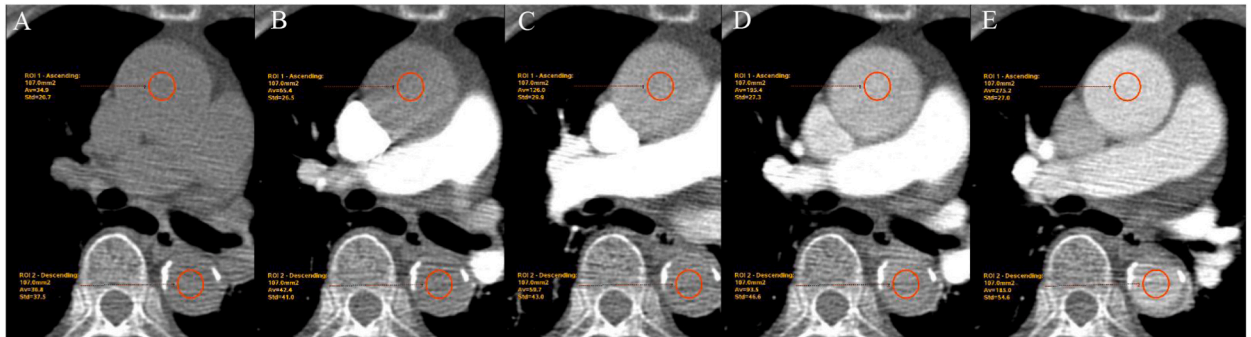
Retrospective analysis of monitoring images in a 74-year-old women underwent single energy scan. (A) The monitoring of tracheal bifurcation levels at the 8 s after the contrast injection. The ascending aortic region of interest (ROI) had a background computed tomography (CT) value of 34.8 hounsfield unit (HU) and the descending aortic ROI had a background CT value of 34.9 HU; (B–C) The contrast agent circulated from the superior vena cava to the pulmonary artery; (D) The CT values in ascending aortic ROI was 195.1 HU, which firstly reached the trigger threshold (CT value > 100), while the CT values in descending aortic ROI was 91.5 HU, which did not reached the trigger threshold. (E) The CT values ascending aortic ROI was 272.2 HU and was 188.1 HU in the descending aortic ROI after a 2 s blood circulation (monitoring sequence with a 1 s exposure time and 1 s interval every 2 s). If monitoring ROI was placed in the ascending aorta, the scan could be triggered 2 s earlier.
